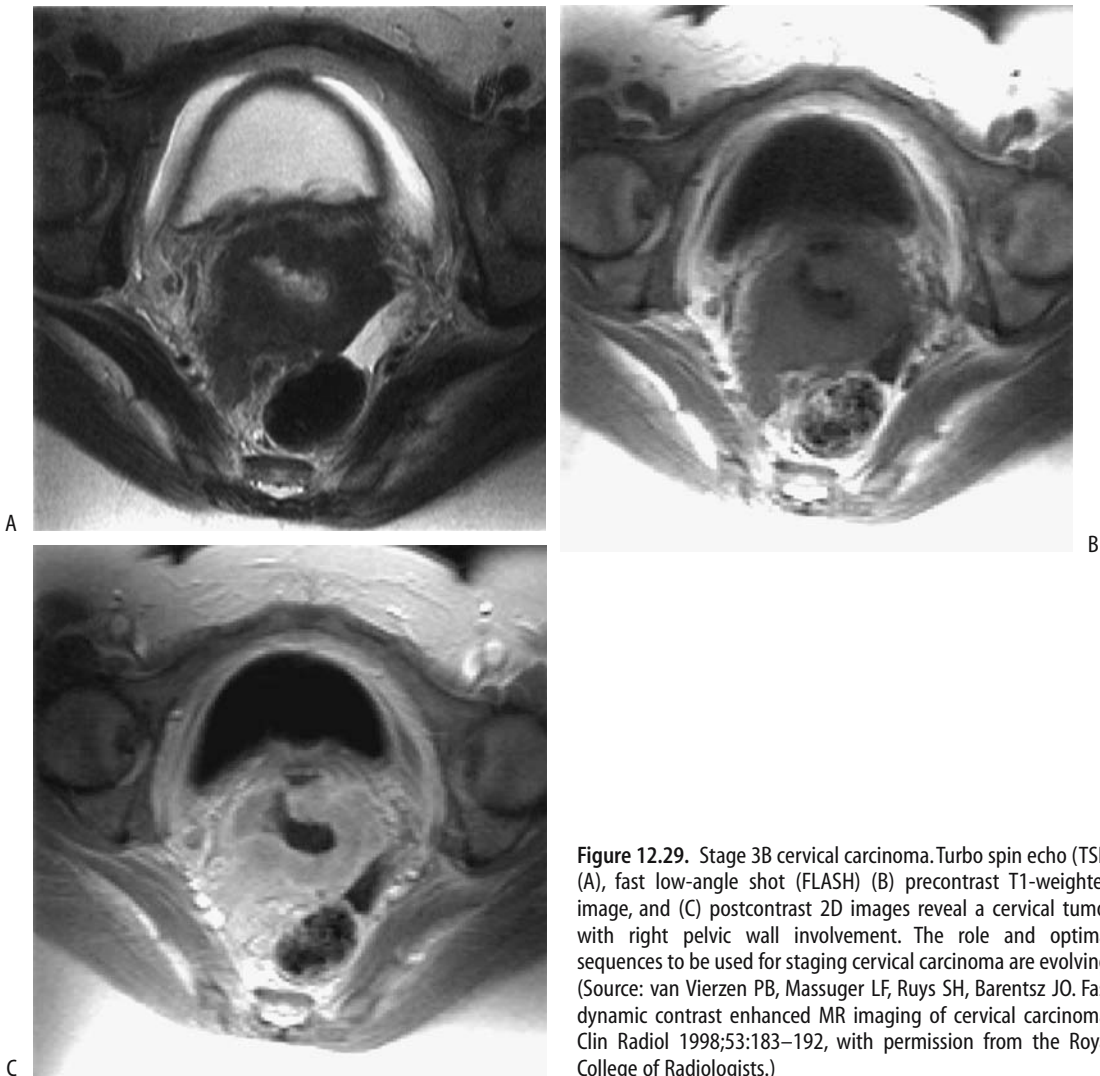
Stage 3B cervical carcinoma. Turbo spin echo (TSE) (A), fast low-angle shot (FLASH) (B) precontrast T1-weighted image, and (C) postcontrast 2D images reveal a cervical tumor with right pelvic wall involvement. The role and optimal sequences to be used for staging cervical carcinoma are evolving. (Source: van Vierzen PB, Massuger LF, Ruys SH, Barentsz JO. Fast dynamic contrast enhanced MR imaging of cervical carcinoma. *Clin Radiol* 1998;53:183–192, with permission from the Royal College of Radiologists.)
